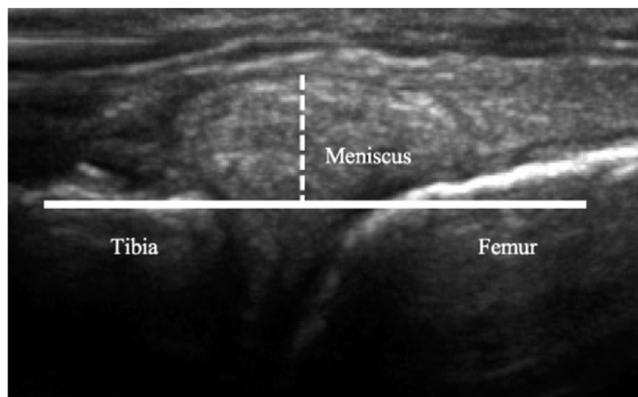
Ultrasound image of an extruded medial meniscus in a right knee. The solid white line represents the edge of the joint line, and the dotted line represents a measurement to the point of maximum meniscal extrusion perpendicular to the edge of the joint line. The tibia, femur, and meniscus are labeled.
